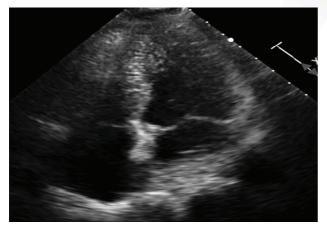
Normal echocardiogram
